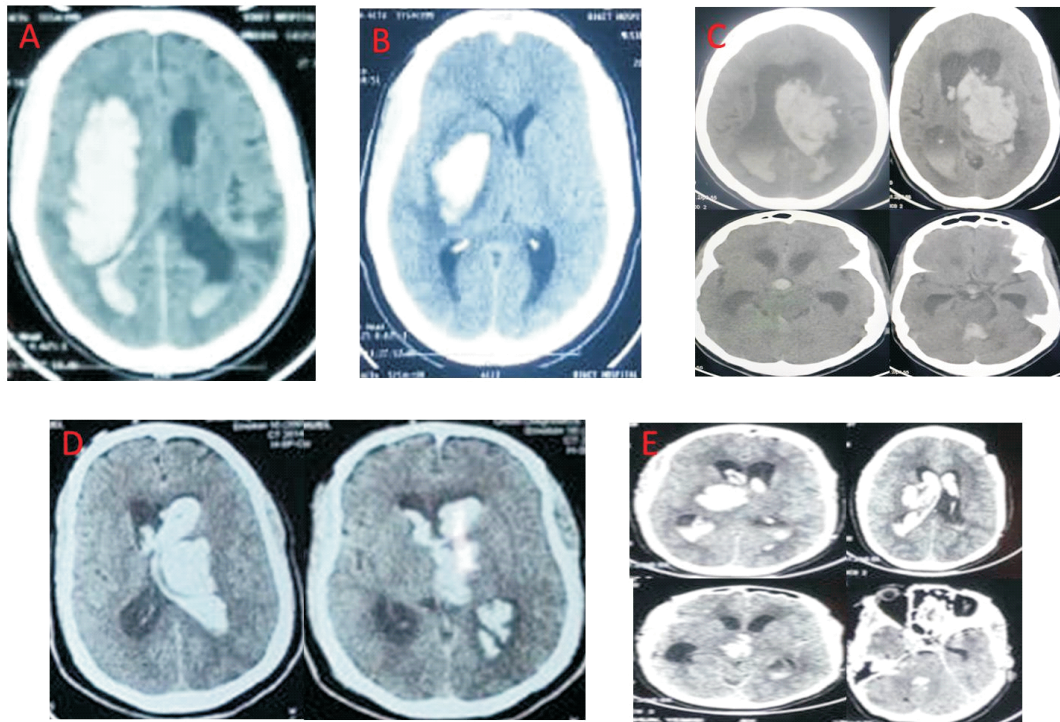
Examples of CT findings and appearances {A. 65yoM-Right-sided lobar haematoma with bilateral IVH; B.41yo M- Deep right-sided lobar haematoma with pressure effects; C. 50yoF – Left thalamic haematoma with IVH (all ventricles) and obstructive hydrocephalus; D. 50yoM – Left thalamic haematoma with bilateral IVH; E. 48yoF – Right basal ganglia haematoma with IVH (all ventricles)}
